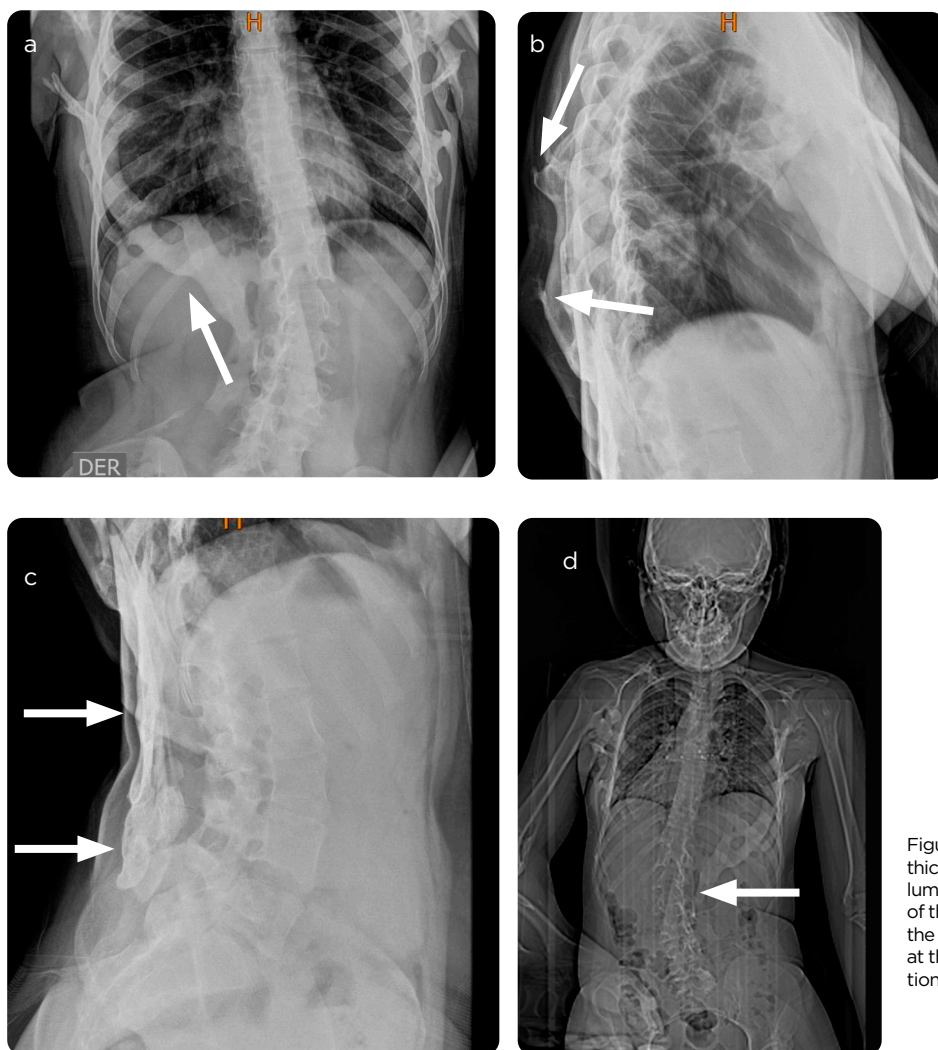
Plain spine X-ray. a) AP projection: prominent thick calcification in the soft tissues of the right thoracolumbar region (arrow). b) Lateral projection at the level of the thoracic spine: ligamentary calcifications next to the posterior dorsal arches (arrow). c) Lateral projection at the level of the thoracic spine: ligamentary calcifications next to the posterior dorsal arches (arrow). d) Anteroposterior projection of the thoracic spine: ligamentary calcifications next to the posterior dorsal arches (arrow).
